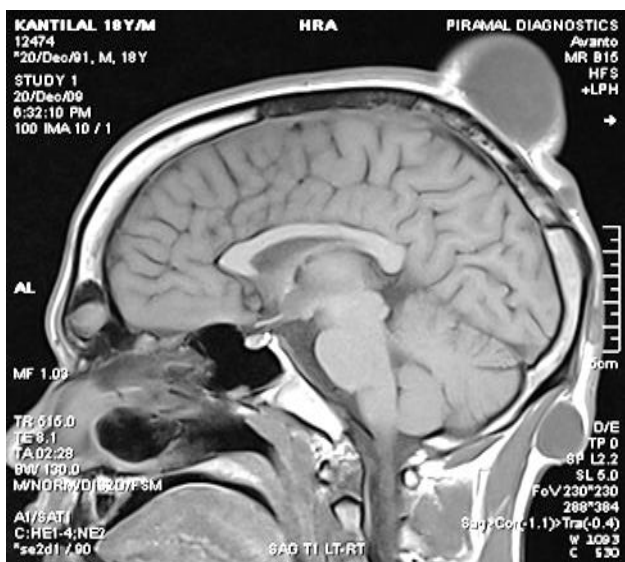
MRI head showed multiple focal well delineated cystic scalp lesions.
